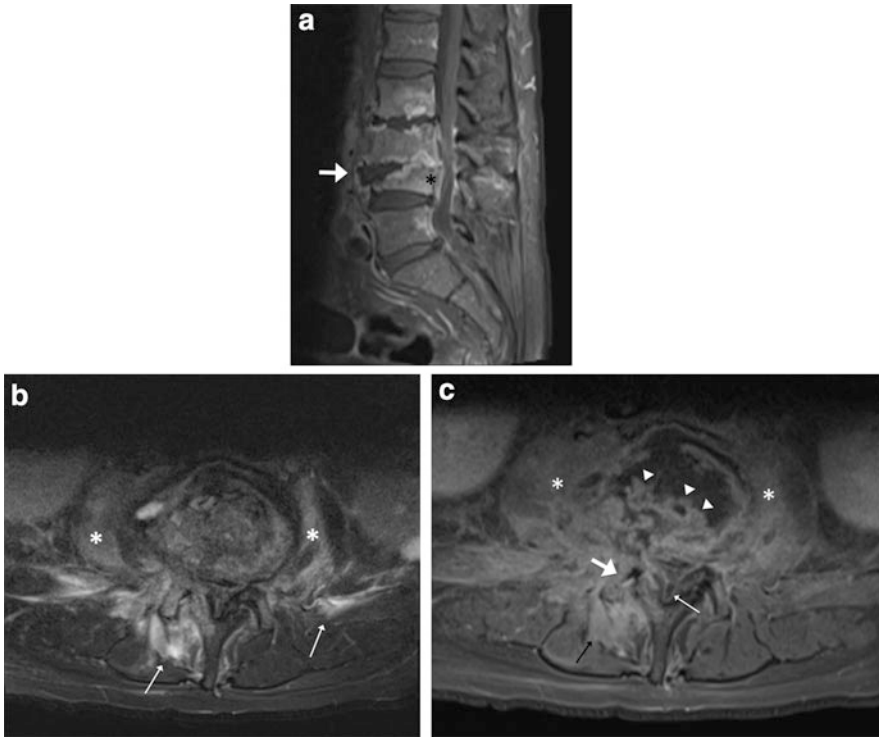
(a) MRI spine showing epidural abscess. Sagittal post-gadolinium T1 FS images of the lumbar spine demonstrate peripherally enhancing intervertebral abscess (white arrow) and significant destruction with loss of height of the L3 and L4 vertebral bodies. Further, endplate destruction is present at L2-3 level. There is intraosseous enhancement in the vertebral bodies from L2 to L5 consistent with osteomyelitis. The enhancing epidural abscess (asterisk) is causing narrowing of the spinal canal. (b) MRI spine showing intervertebral discitis. The axial STIR image at the level of L3-4
